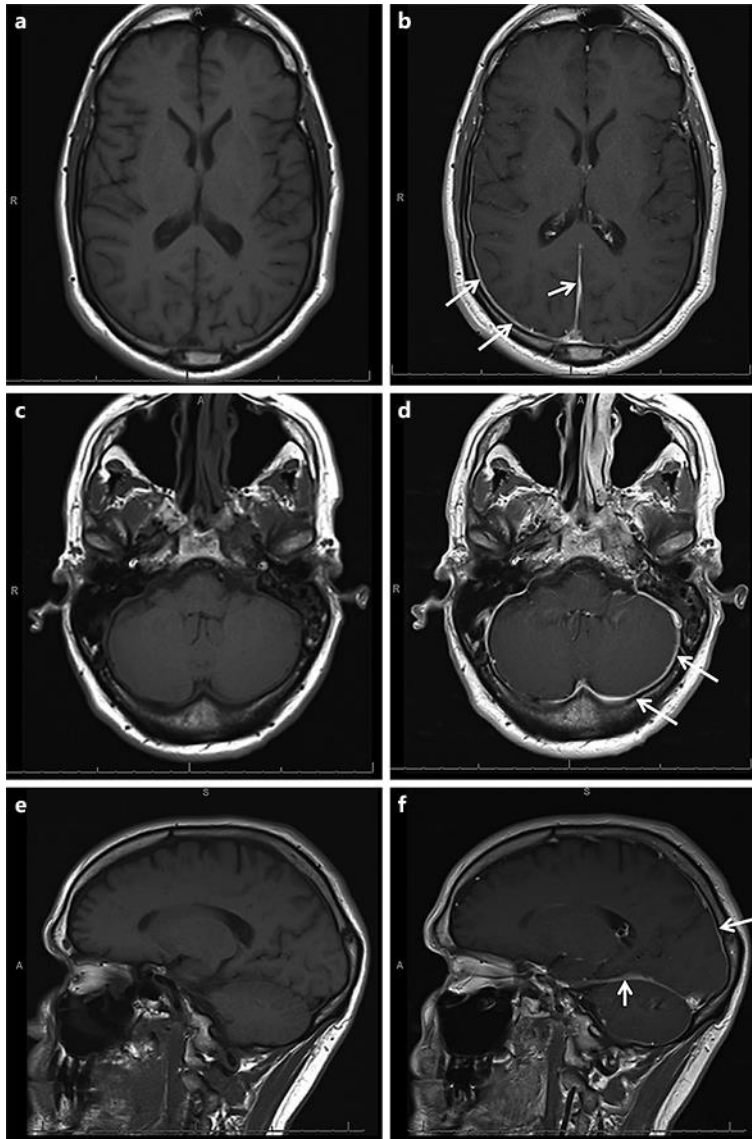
T1-weighted pre- and post-contrast sequences showing contrast enhancement of pachymeninges (arrows). a, c Axial T1 pre-contrast. b, d Axial T1 post-contrast. e Sagittal T1 pre-contrast. f Sagittal T1 post-contrast.
